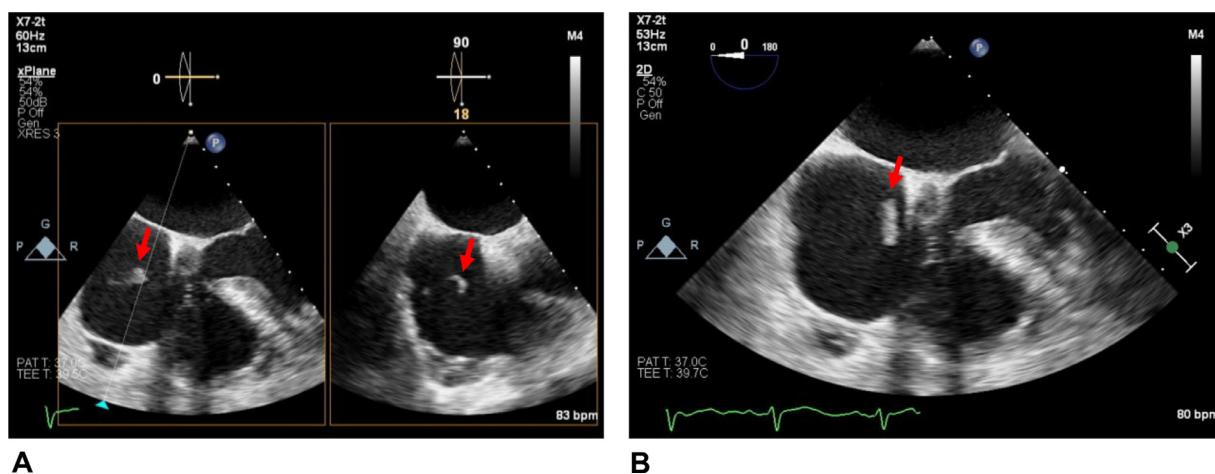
Transesophageal echocardiogram (TEE) with different probe orientation showing mobile, elongated vegetation (red arrow) arising from the atrial side of the tricuspid valve.
